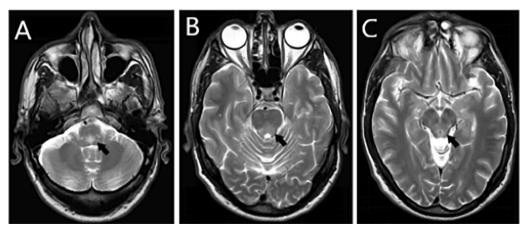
Axial turbo spin echo T2-weighted magnetic resonance imaging sequences. A Patchy hyperintensity in the central portion of the medulla oblongata (black arrow). B Hyperintensity in the posterior region of the pons (black arrow). C Hyperintensity in the midbrain, involving the tegmentum (black arrow)
